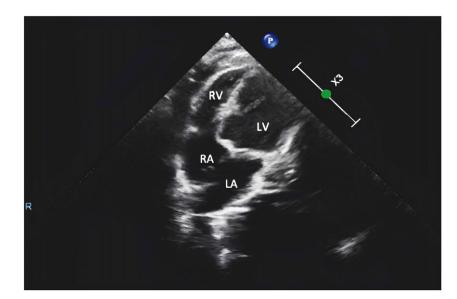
View of the post-operative four-chamber echocardiogram.
